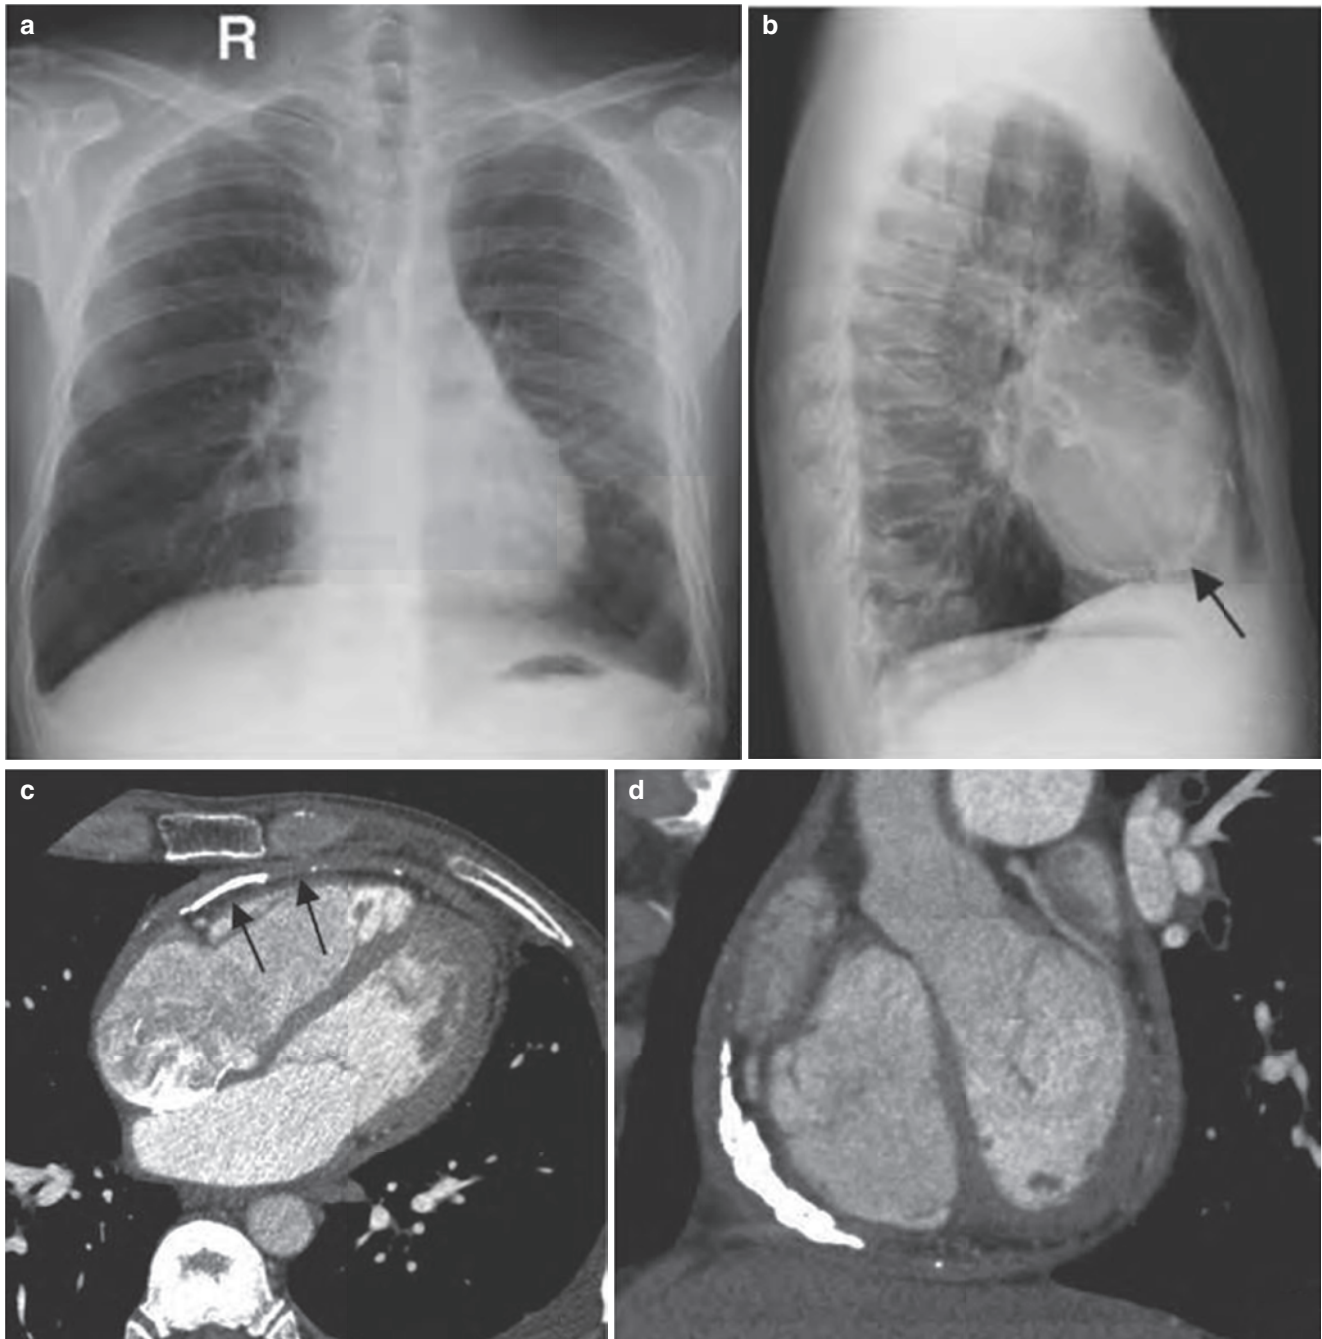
Constrictive pericarditis (I). (a, b) Chest radiograph showed diffuse pericardial thickening (arrow) and (c, d) CT enhanced scan of the heart showed thickened pericardium with stripe-like calcification (arrow) and slightly enlarged right atrium
